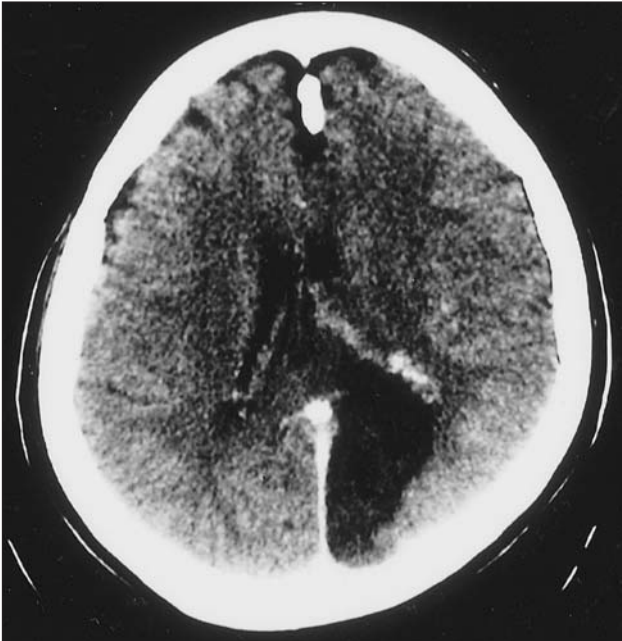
Case 1: Preoperative contrast axial CT scan shows infarct on the feeding area of left PCA.
